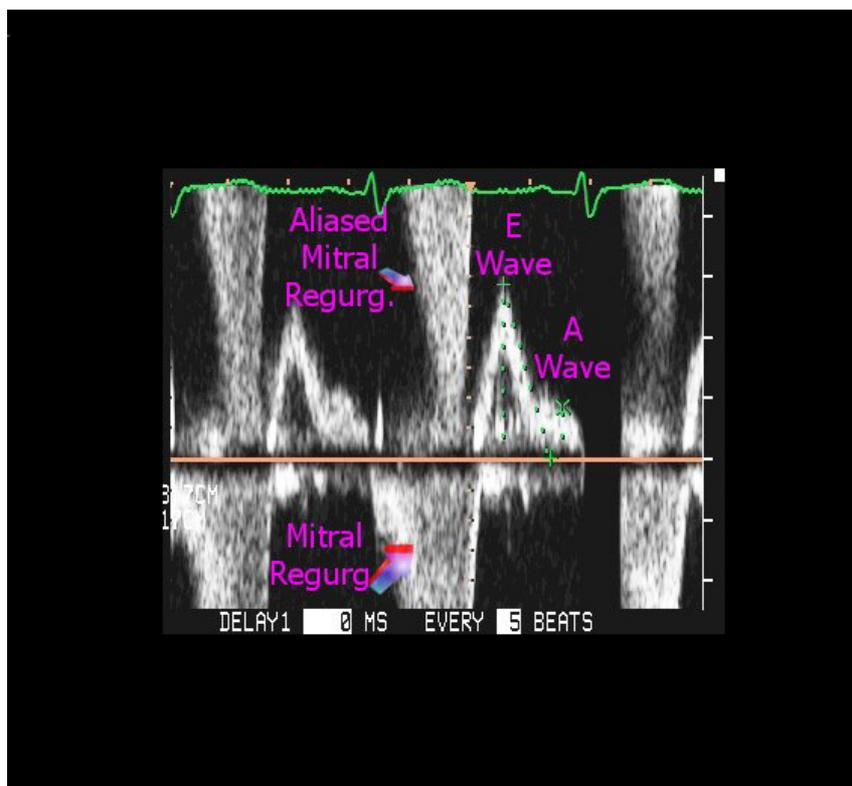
This Pulsed Wave Doppler of mitral inflow shows an aliased mitral regurgitation waveform: http://www.heartweb.com.au/Videos/Echobk/CH3/Aliasing_PW.jpg
